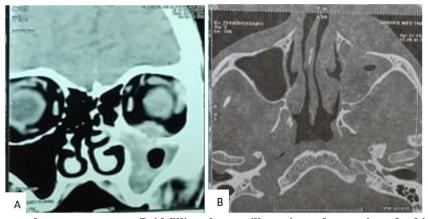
CT scan shows edematous mucosa, fluid filling the maxillary sinus, destruction of orbital floor and bone margins. A: coronal view, B: axial view
